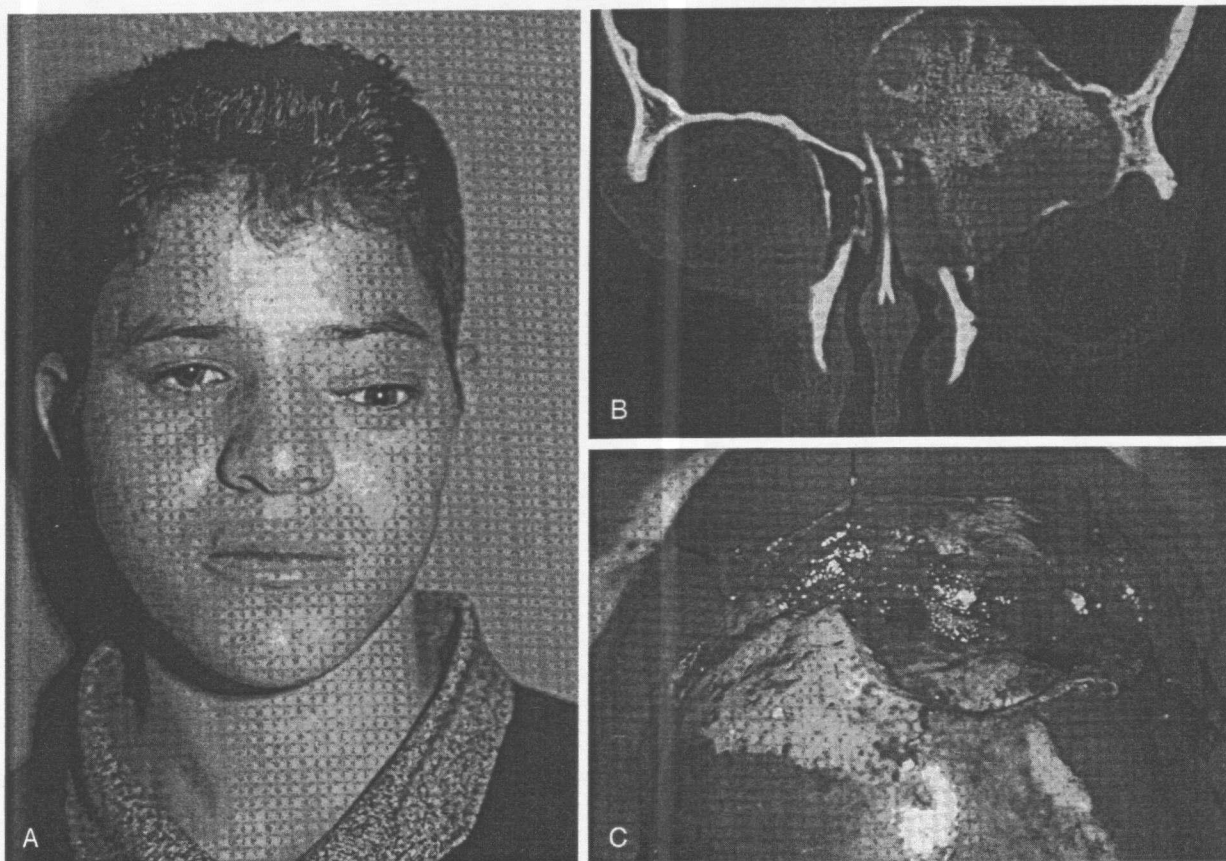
A, Patient with significant vertical orbital dystopia secondary to FD involvement of the orbital roof. B, Computed tomographic scan (coronal view) demonstrating FD of the orbital roof. C, Intraoperative view of frontoorbital approach.
